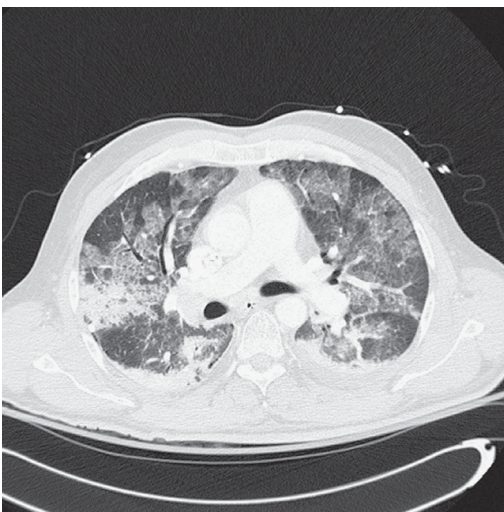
CT scan of the chest shows diffuse bilateral ground-glass opacities.
